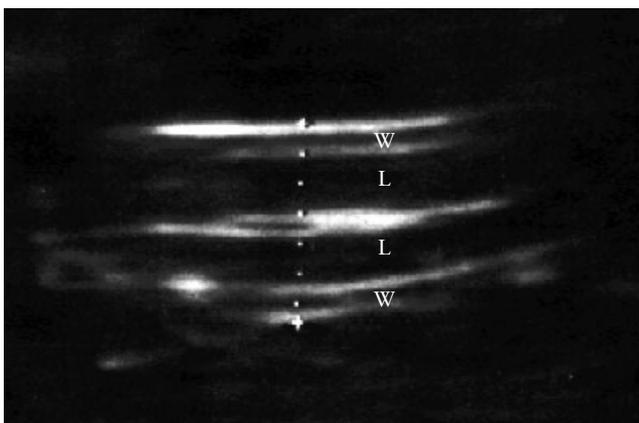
Umbilical cord at 12 weeks of gestation in a normal fetus. The beam of the ultrasound transducer is perpendicular to the surface of the umbilical cord and six parallel echogenic lines are seen. The outer two lines are the margins of the cord and the internal four represent the walls of two vessels. The intervening gray areas are due to the Wharton's jelly (W) and the translucent areas represent the lumen of the vessels (L).
